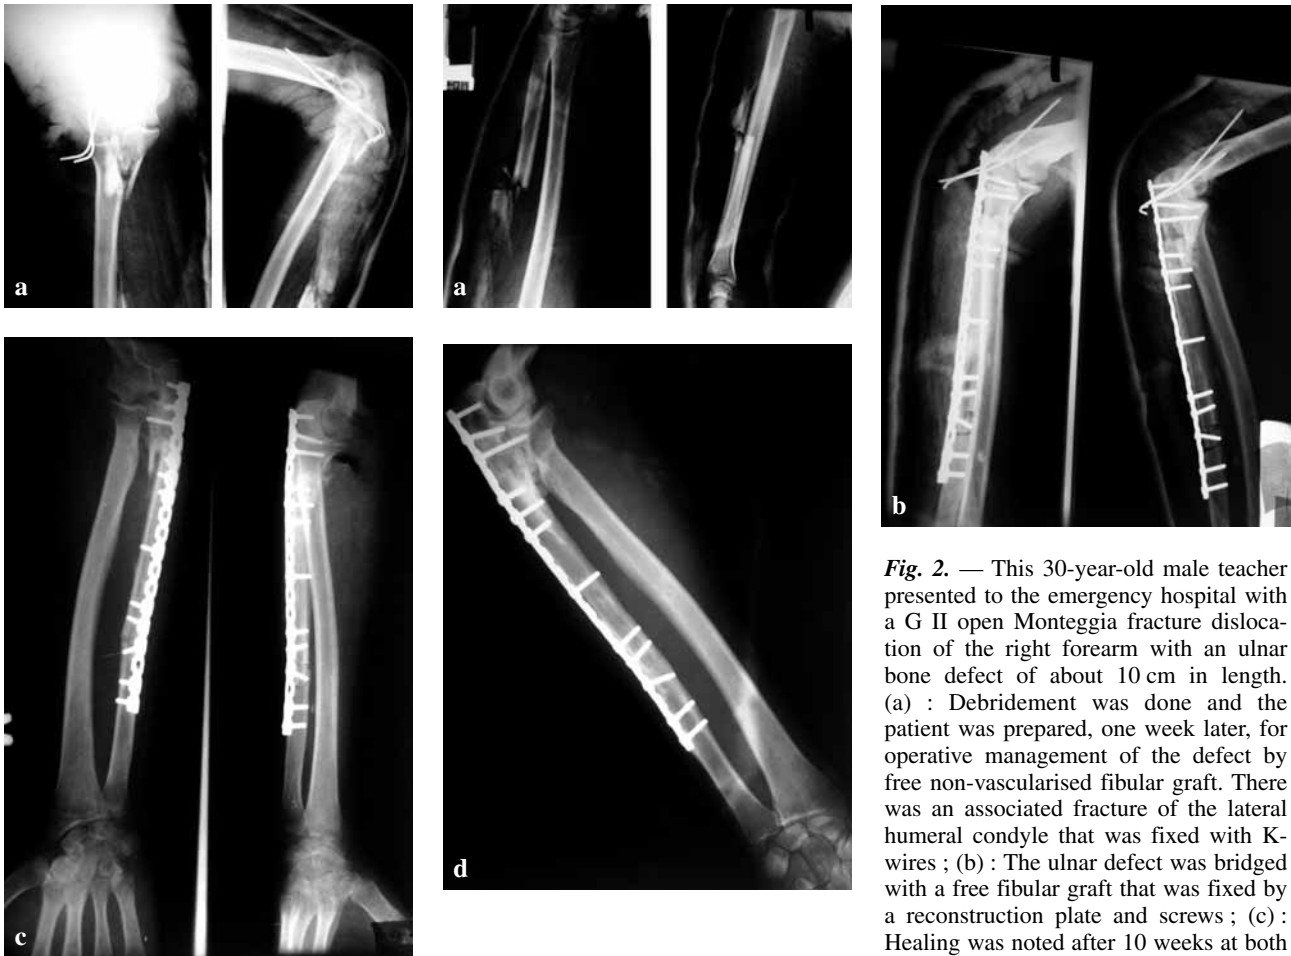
This 30-year-old male teacher presented to the emergency hospital with a G II open Monteggia fracture dislocation of the right forearm with an ulnar bone defect of about 10 cm in length. (a) : Debridement was done and the patient was prepared, one week later, for operative management of the defect by free non-vascularised fibular graft. There was an associated fracture of the lateral humeral condyle that was fixed with K-wires ; (b) : The ulnar defect was bridged with a free fibular graft that was fixed by a reconstruction plate and screws ; (c) : Healing was noted after 10 weeks at both ends of the fibular graft ; (d) : Radiographs taken after 3.5 years showing hypertrophy of the fibula.
